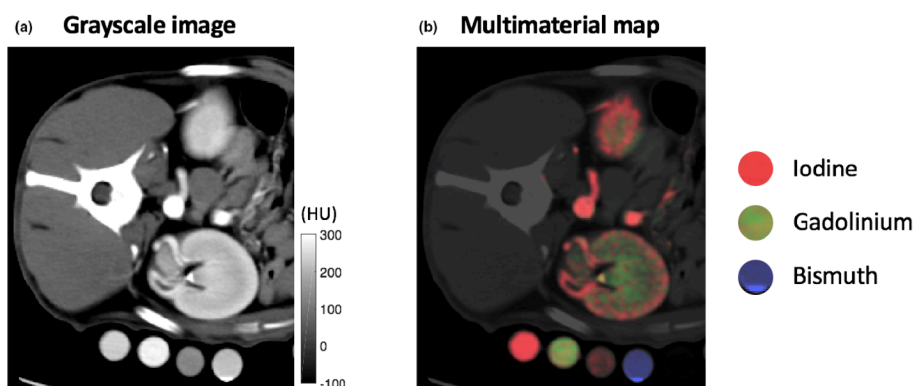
Multimaterial decomposition using photon-counting detector technology CT
